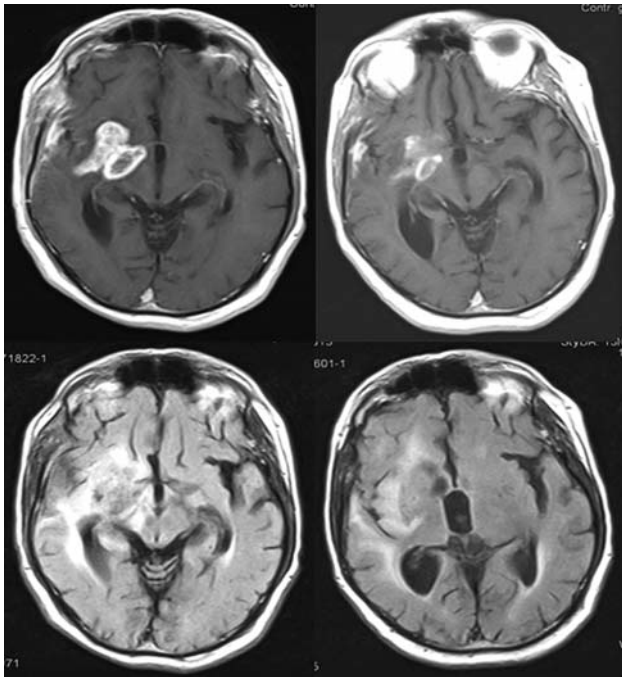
Magnetic resonance imaging of a partial response: gadolinium-enhanced (top) and T2 fluid-attenuated inversion recovery (bottom).
